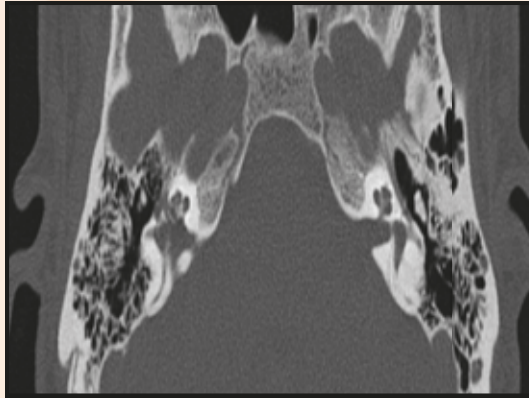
Axial CT scan of the temporal bone showing a transverse fracture.
